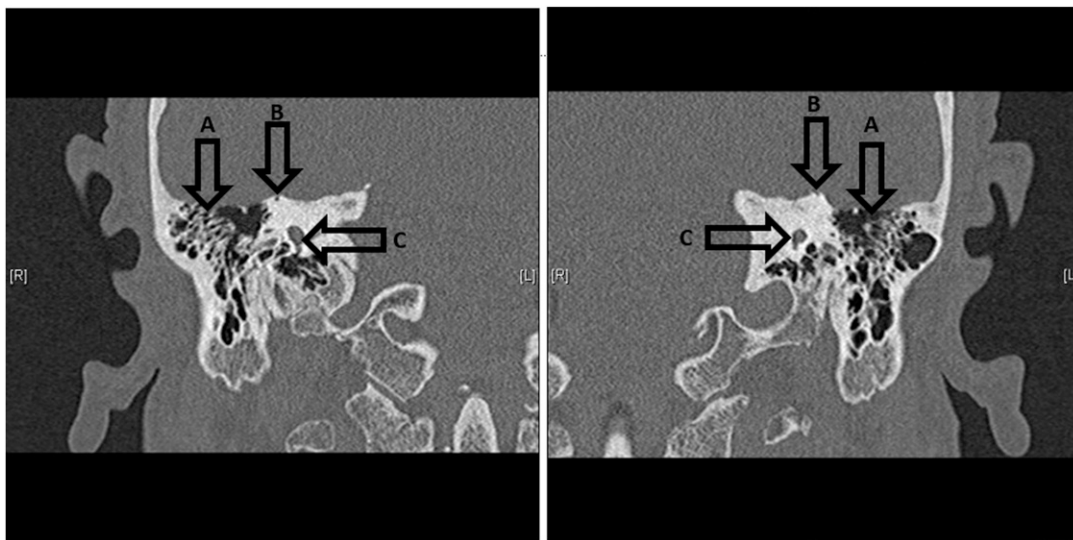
Coronal CT scan image showing evidence of bilateral SSCD. The image on the left is the right ear, and the image on the right is the left ear. Arrows show anatomical landmarks for both ears. A = mastoid air cells, B = SSCD (divot indicates lack of bone where the roof of the superior semicircular canal meets the floor of the middle cranial fossa), and C = vestibule. [R] = patient right ear and [L] = patient left ear.
